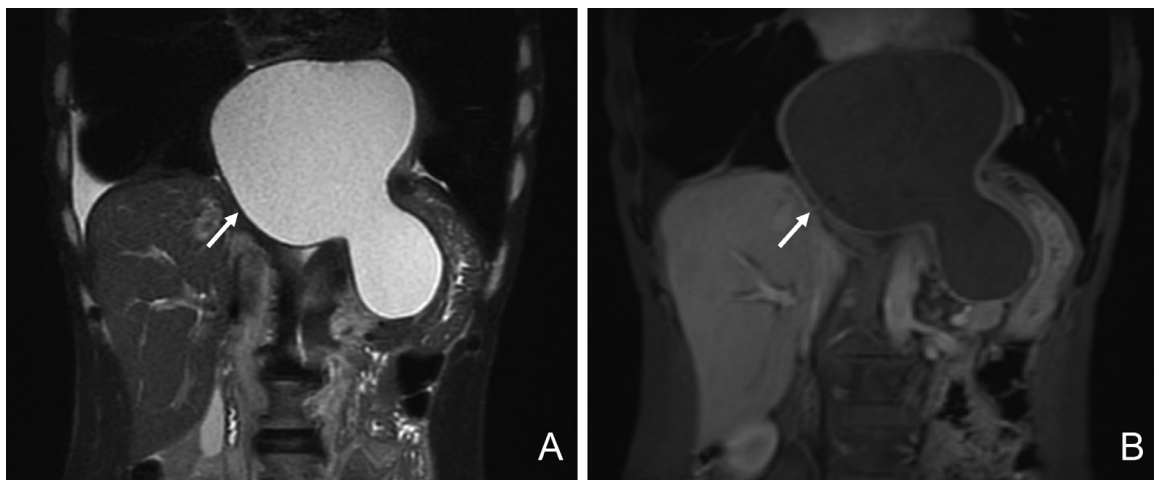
Abdominal MRI scan (coronal) reveals a pseudocyst with long T2 signal extending from the tail of the pancreas to the posterior mediastinum (white arrow in A) and with ring enhancement on enhanced scan (white arrow in B).
